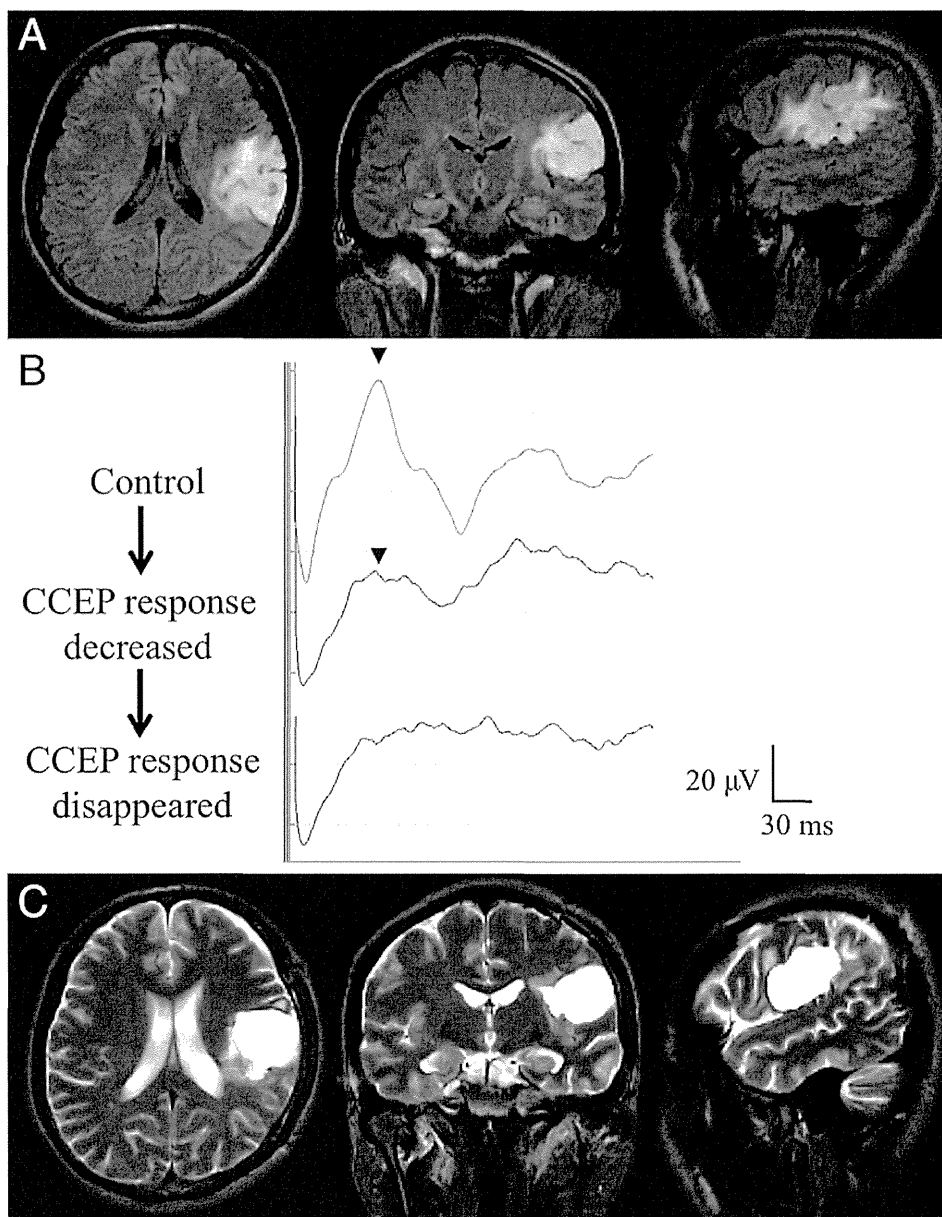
Case 8. Oligodendroglioma in a 33-year-old man. Preoperative MR images (A) demonstrated tumor in the left inferior parietal lobule. The neoplasm was resected during awake craniotomy, and intraoperative CCEP monitoring was performed with stimulation of the TLA and recordings from the FLA. During surgery, paraphasia, repetition failure, and dysarthria were noted. An initially normal CCEP response demonstrated a decrease in amplitude and occasionally disappeared (B). The resection rate was 95% (C). After surgery, the patient experienced prolonged speech dysfunction with slow recovery within 15 months of follow-up.
